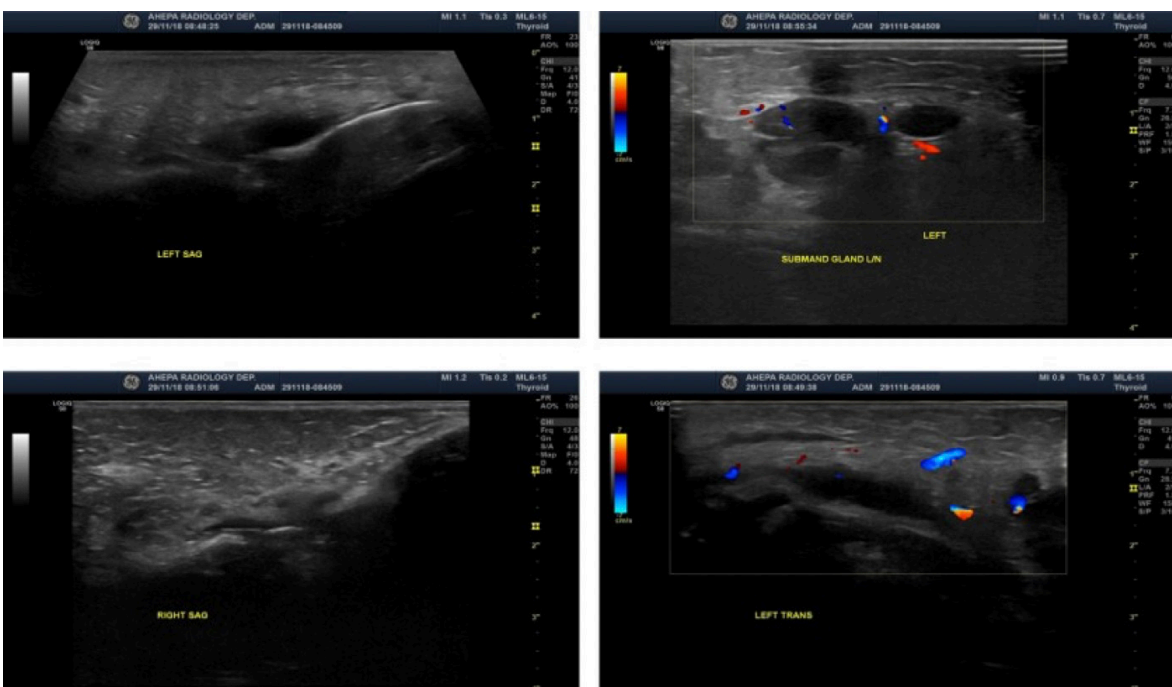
USG images revealed abscess formation superficial to the ramus of the lower jaw, subcutaneous edema and increased vascularity in Color Doppler. Expansion of the lesion to the adjacent tissues apparent thickening of the skin, and presence of abnormally enlarged lymph nodes in the underlying region.
